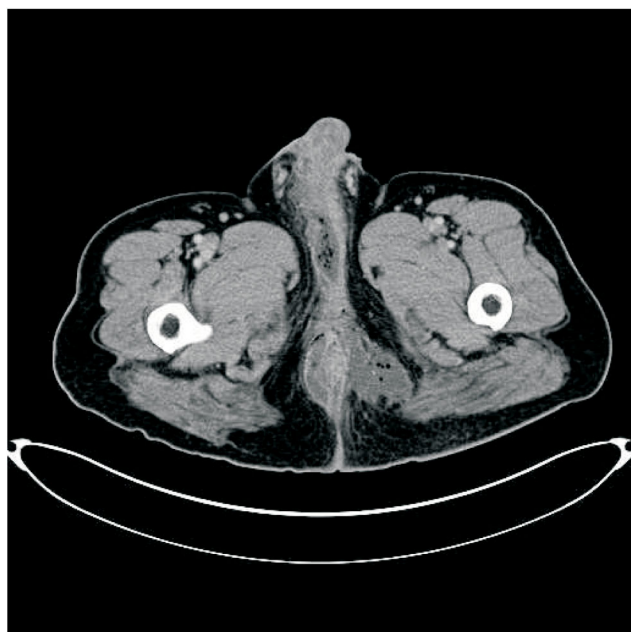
Abdominal CT scan showed the location and extent of the abscess.
